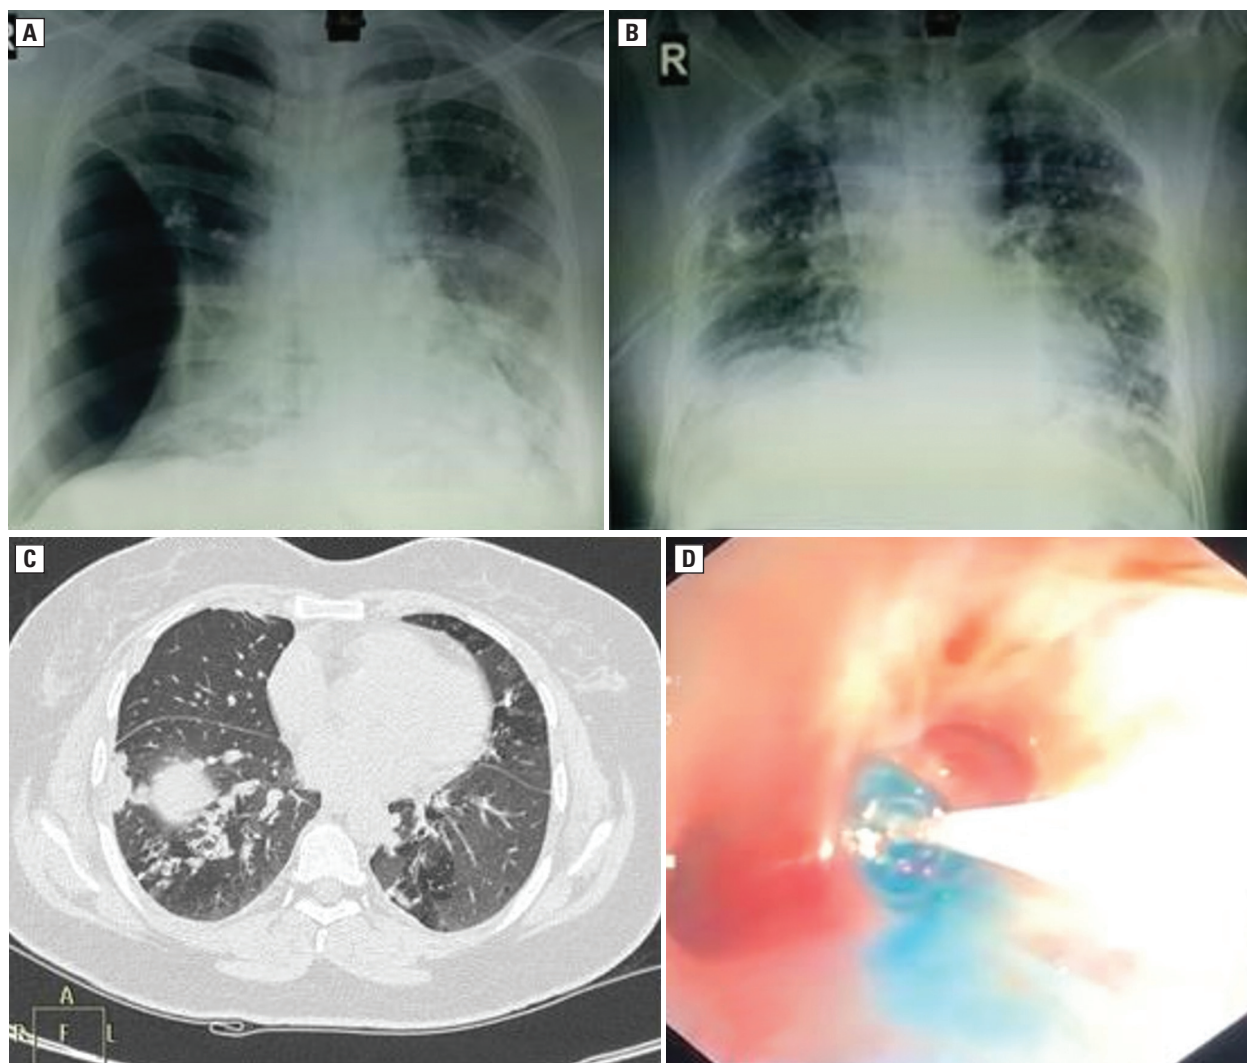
Chest Skiagram showing right sided pneumothorax; B. Chest skiagram showing resolved pneumothorax post intrabronchial instillation of cyano-acrylate glue; C. Computed tomography of chest showing bilateral rheumatoid nodules; D. Fibreoptic bronchoscopic picture showing intrabronchial glue installation
